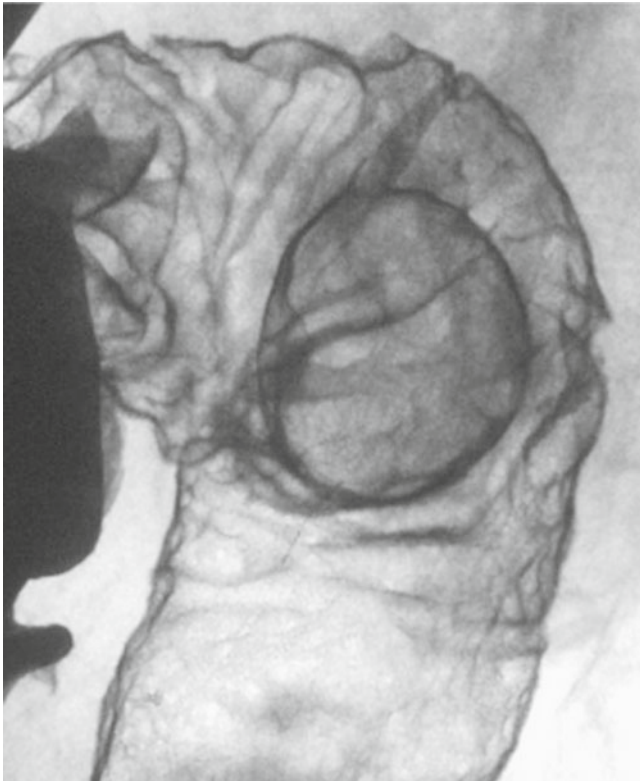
Radiography showed a semi-pedunculated, elevated lesion with a smooth surface in the terminal ileum
